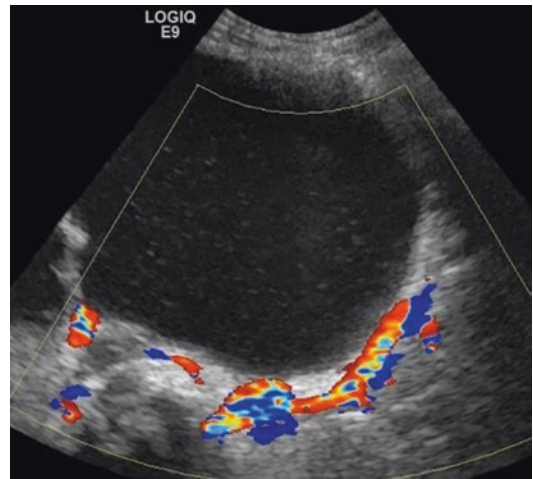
Crossing vessels associated with UPJ obstruction in a 3-year-old boy. Color Doppler displays two crossing vessels, one artery and one vein, at the level of the dilated system
